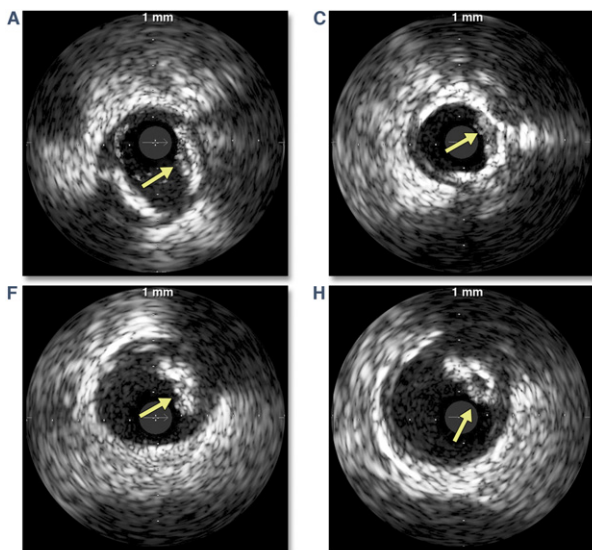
Intravascular Ultrasound
